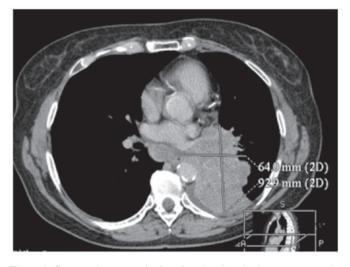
Computed tomography imaging showing the lung tumour at the time of diagnosis.
